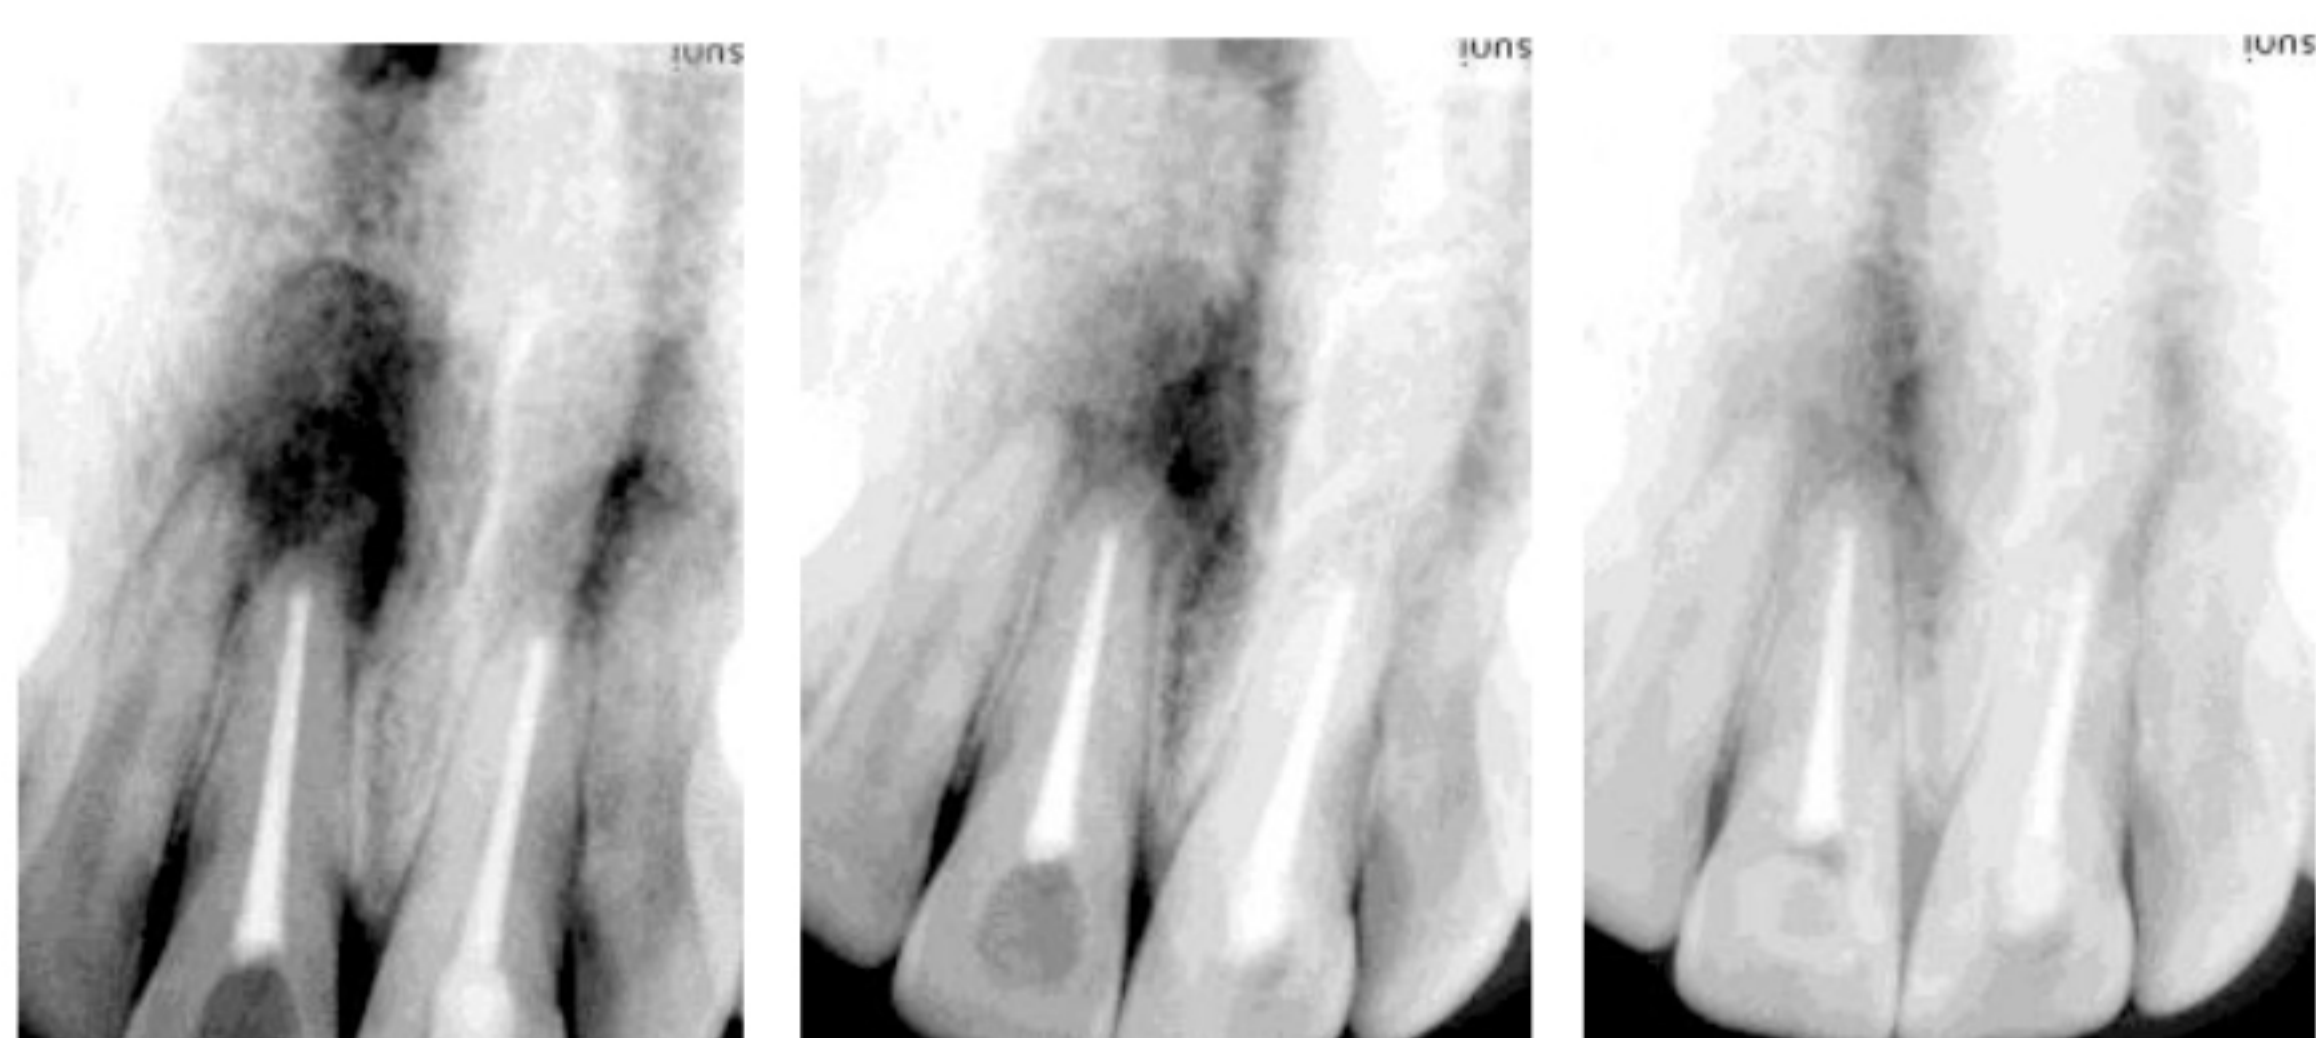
Pre operative, 6 and 9 month post operative digital radiograph
